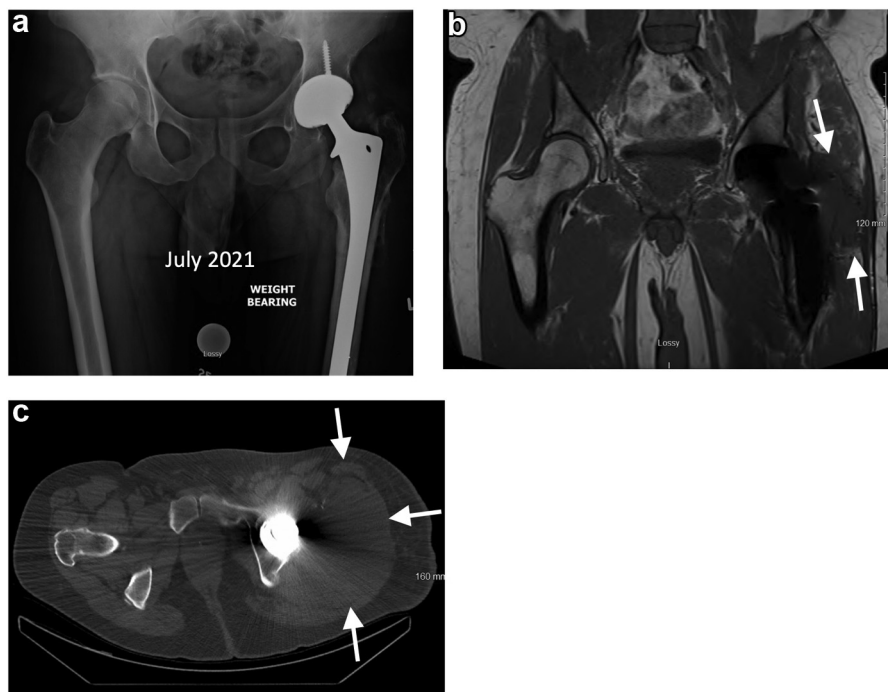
(a) Anteroposterior radiograph of pelvis and left CoC THA at 11 years postoperatively. (b) T1 weighted coronal MRI of pelvis and hip initially suggesting of left-sided periprosthetic pseudotumor forming inflammatory changes. (c) Axial MRI of pelvis displaying a mass of size $9 \times 8 \times 10$ cm in left hip, as depicted by the arrows (July 2021).
